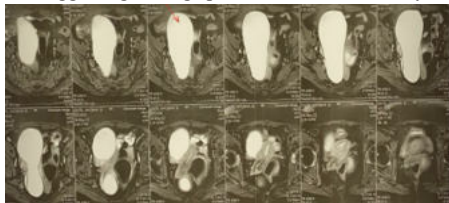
MRI showing a well-defined, thin-walled cystic lesion in the right adnexa, medial to the right ovary
